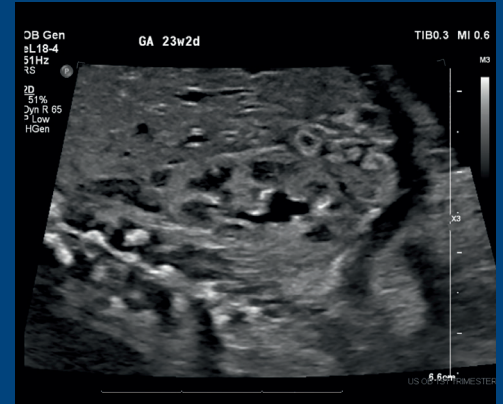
Ultrasound image with the eL18-4 transducer.
